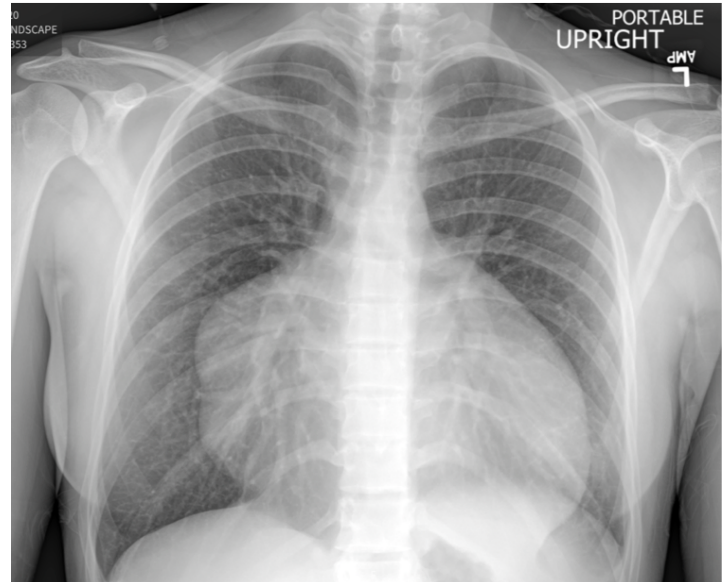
Chest X-ray (CXR) at presentation showing enlarged cardiac silhouette.
